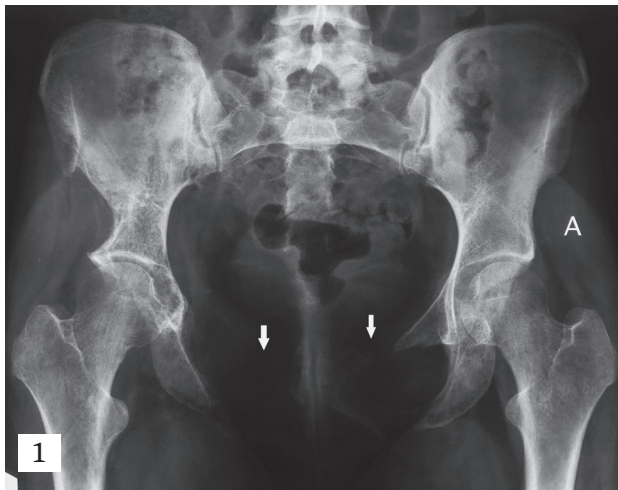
Radiography reveals osteolysis of superior and inferior rami of both pubic bones (arrows) and right inferior ischial ramus. There is disruption of iliopectineal line at right side. Bone ends at the region of osteolysis are “pointing”
